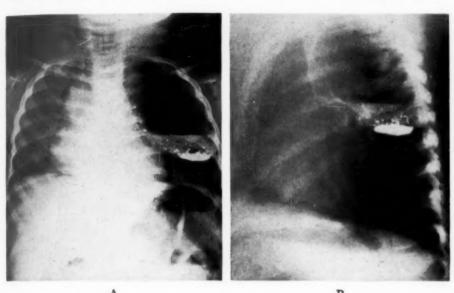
Case 8: A. Roentgenogram taken after aspiration of cyst contents and replacement with air and small amount of lipiodol.
